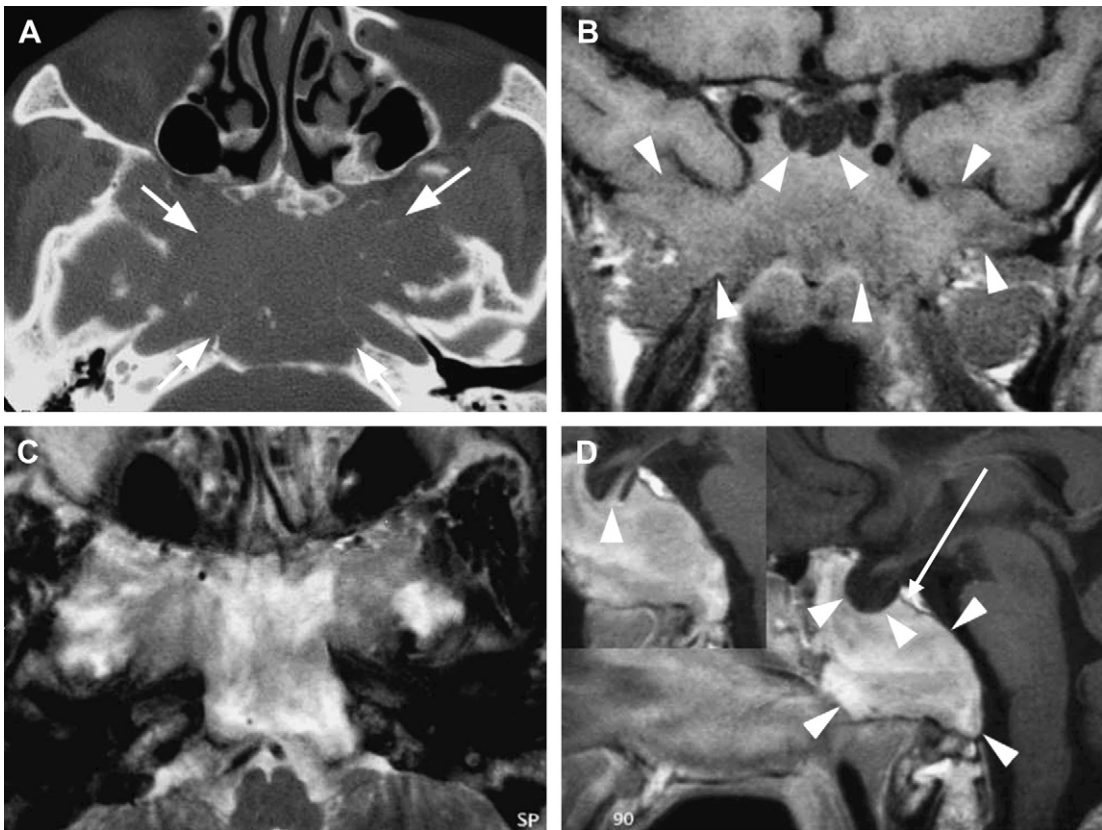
Axial CT scan in a bone algorithm shows a large destructive lesion almost entirely replacing the sphenoid bone (A), retaining its original shape and with small bony fragments engulfed within the lesion (*white arrowheads in B*). Coronal T1-weighted (B) and contrast-enhanced sagittal T1-weighted (D) MR images show to advantage the soft tissue mass delineating the sphenoid (*white arrowheads*). Note the presence of an empty sella (*black arrowheads*), the inferior displacement of the sellar floor, and the rightward deviation of the pituitary stalk. The high signal intensity of the neurohypophysis can be seen in a normal anatomic location (*long white arrow in D*). (C) On T2-weighted imaging, the lesion is heterogeneous in signal intensity but predominantly hyperintense (intra-osseous pituitary adenoma).
